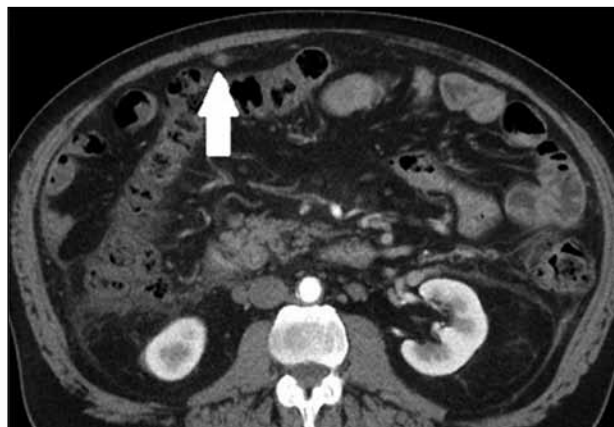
Axial triphasic computed tomographic scan of the abdomen shows a dilated vascular structure in the falciform ligament (arrow).
